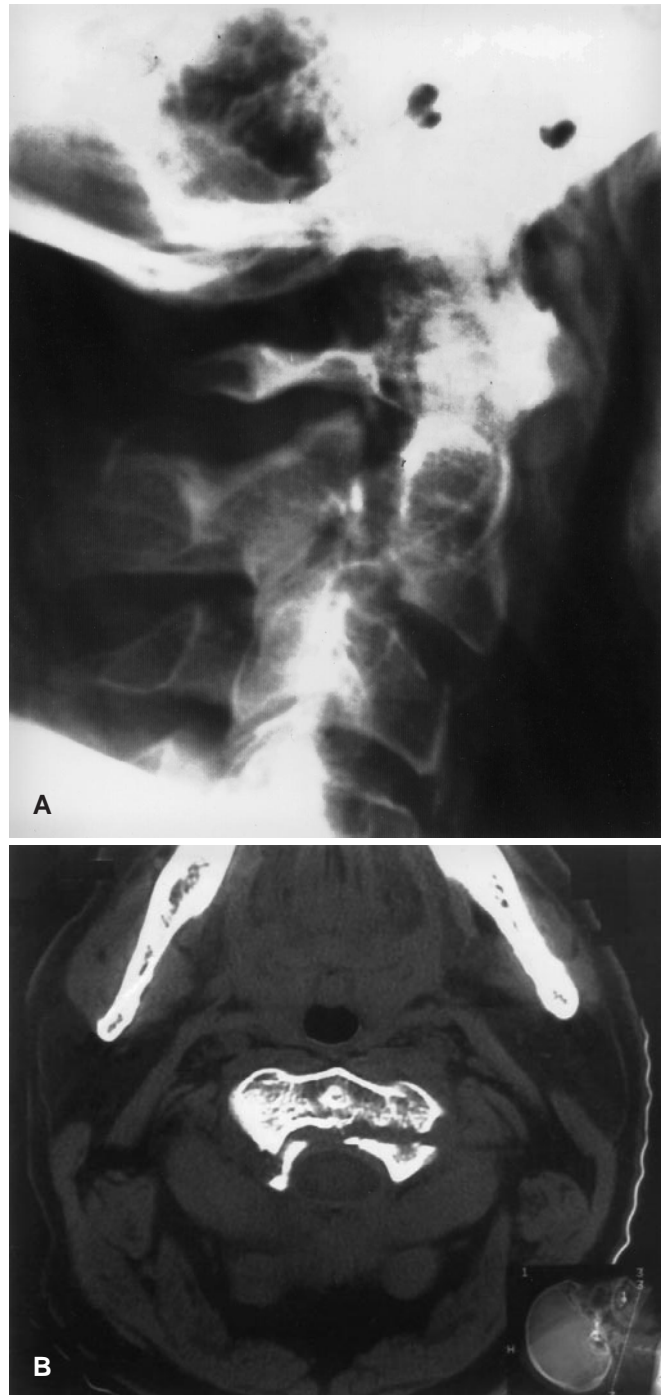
A Type II flexion injury associated with an impaction of the C3 superior end plate. B Computed tomographic scan of the injury, demonstrating the atypical configuration of the pedicle fracture
